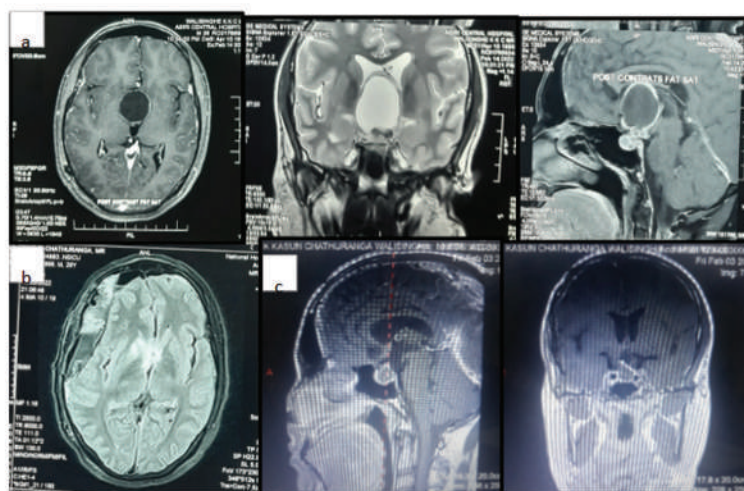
MRI brain with the pituitary protocol of the index patient
